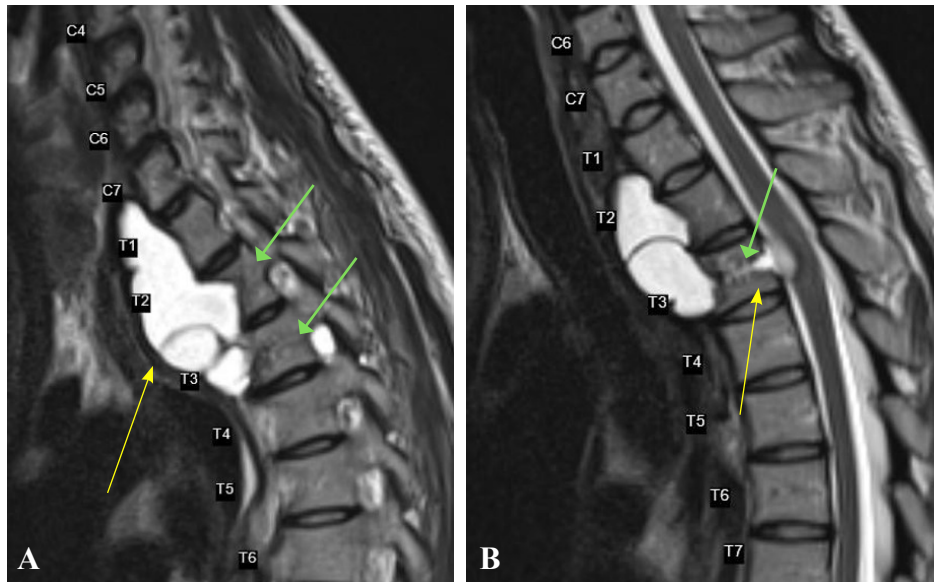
An MRI scan from 2024 indicating the cranio-caudal extent of the paraspinal hydatid cyst (yellow arrow A) and the protrusion of cystic contents into the spinal canal (yellow arrow B). The green arrows indicate the bone erosion at the T2/T3 vertebral body level (A) and T3 vertebral body (B)
